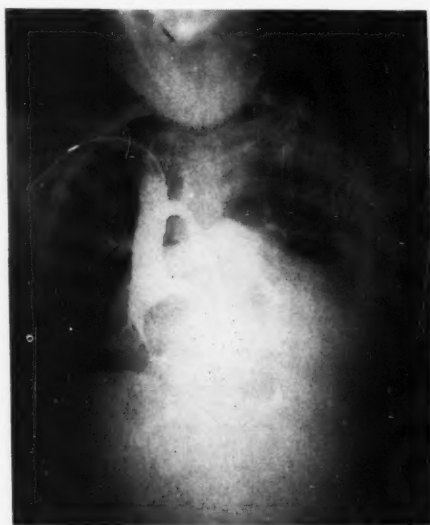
Roentgenograms of chest. Note the gross enlargement of the heart both to left and right.
